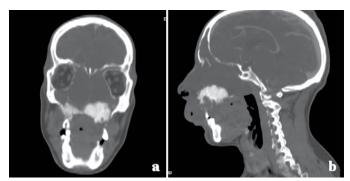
Computed tomography scan after injection of contrast medium. (a) Coronal and (b) Sagittal images demonstrate the lesion originating in the left upper quadrant of the maxilla and invading the nasal cavity and the sphenoidal and frontal sinuses.
